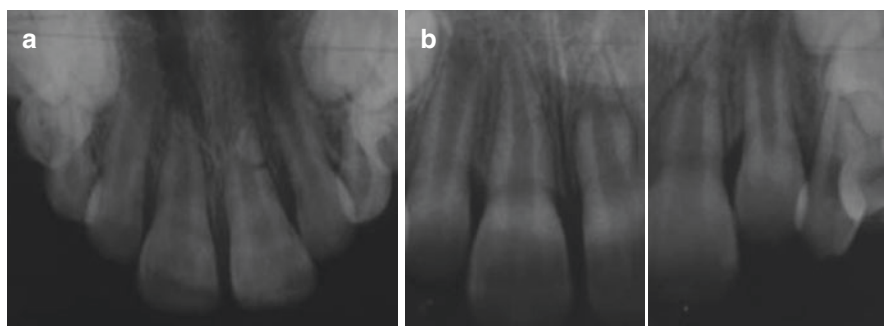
Occlusal (a) radiograph confirms the apical 1/3 root fracture in the upper left central incisor, which was less apparent on the periapicals (b)
